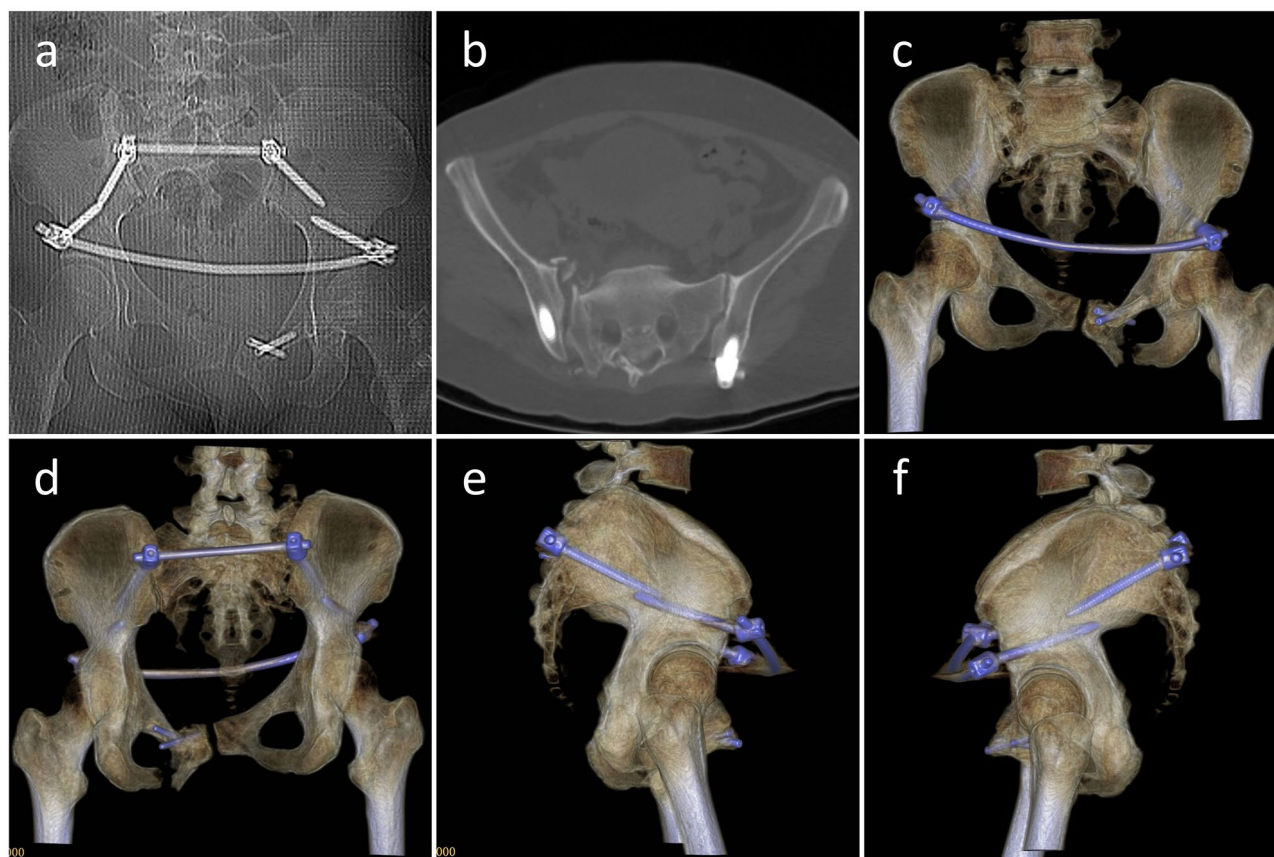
Case 1: CT performed 2 weeks postoperatively showed that the anterior and posterior rings were adequately reset, and the internal fixation was reliable (a–f)
